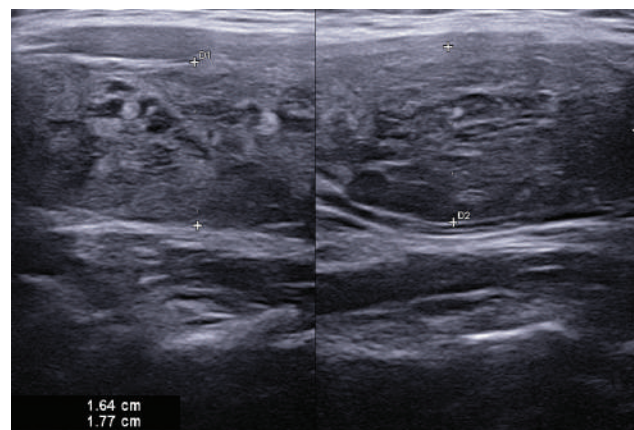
High resolution ultrasound of thyroid gland showing mild thyromegaly with non-homogenous parenchyma giving early nodular change.
